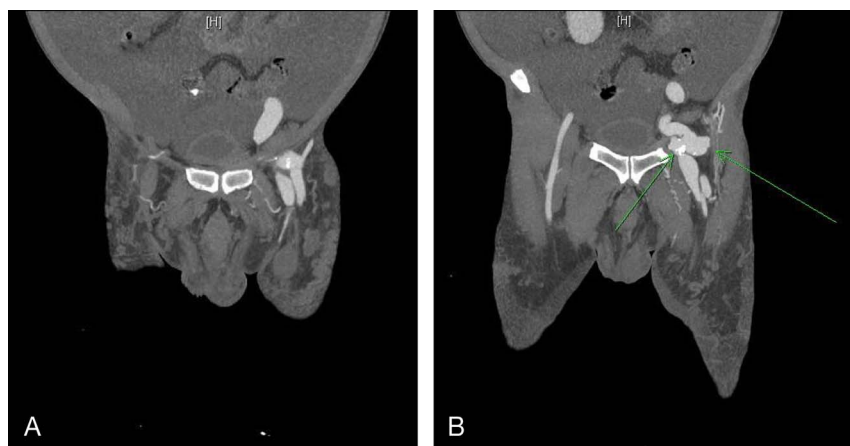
Abdominal CT angiography confirms the AVF at the left external iliac artery/femoral artery level. A, The cross-sectional image of the lower abdomen and pelvic region provides detailed anatomical information about the AVF. B, An abnormal communication (green arrow lines) between the left external iliac artery and the adjacent vein was found, with the affected vessels appearing dilated and showing early contrast enhancement.
